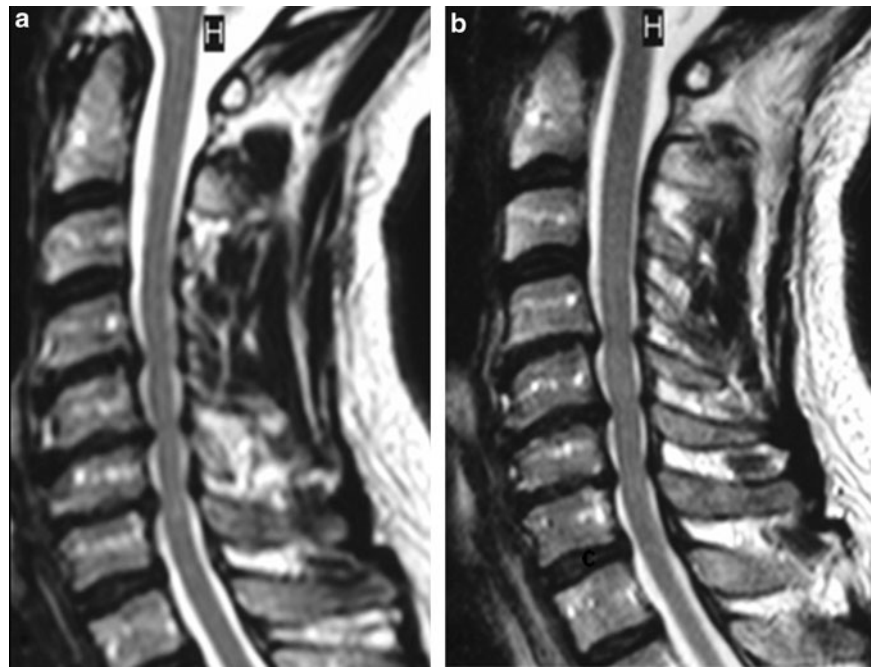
Sagittal and axial T2-weighted MRI, showing a chronic cervical spondylotic myelopathy, with a symmetrical suffering of the central grey matter at multiple levels
